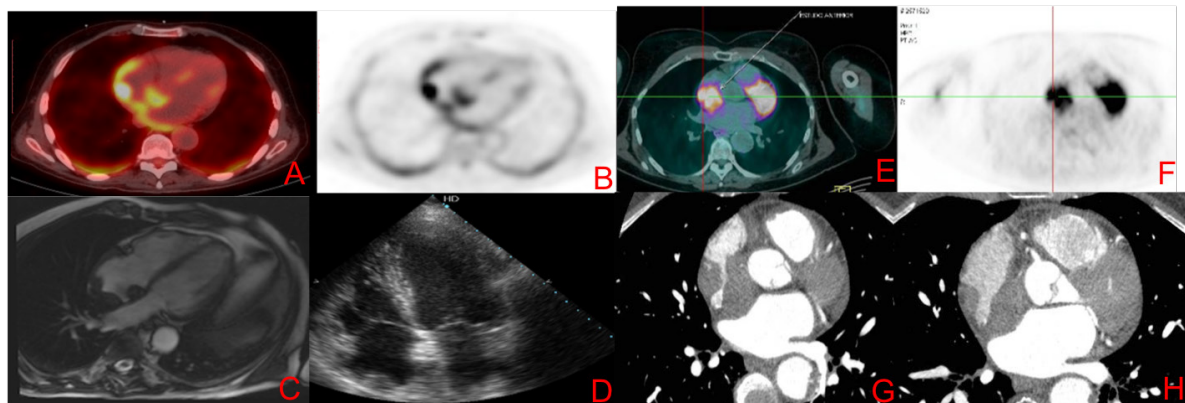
Images A to D refer to case 1 and the images from E to H refer to case 2. Images A and B represent images of 18-FDG PET-CT showing lesion in the right atrium roof. The C image represent CMR image, SSFP cine 4 chambers with hypointense lesion in the right atrium roof. The D image represents a transthoracic echocardiogram image with the same topography. The images E and F represent 18-FDG PET-CT with capturing lesion in the right atrium and G and H images represent contrast computed tomography showing evidence of expansive right atrial.
